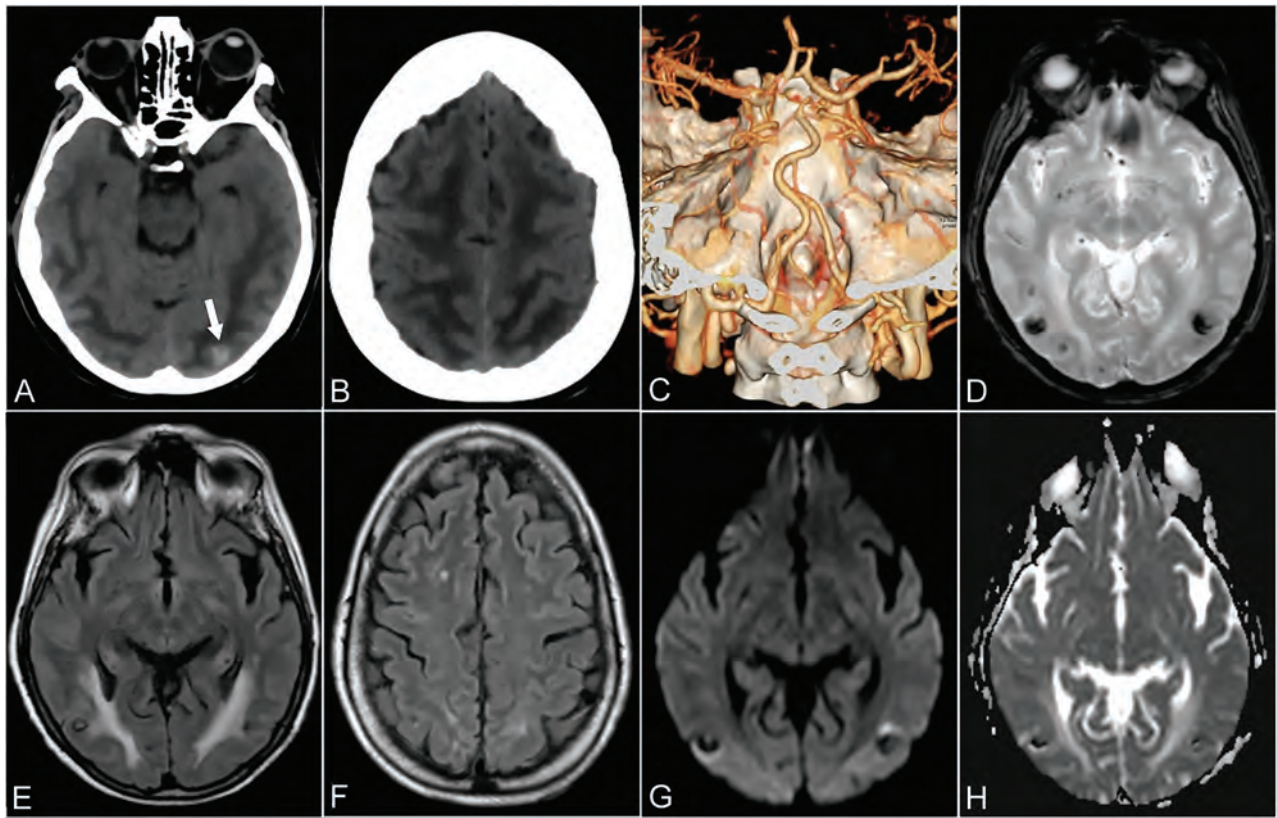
Patient 6. A 64-year-old woman presenting with drowsiness and reduction in visual acuity. Baseline axial CT shows ill-defined, bilateral hemispheric, white matter hypoattenuation, sparing the adjacent cortex, tapering off in the polar aspect of the frontal lobes, consistent with vasogenic edema (A and B). A small hyperattenuating lesion is noted in the left occipital lobe, suggestive of focal bleeding (arrow, A). CTA VR reformatted imaging was unremarkable in appearance (C). Three weeks later axial T2* gradient recalled-echo (D), axial T2 FLAIR (E and F), DWI (G), and an ADC map (H) demonstrate a partial resorption of edema and the presence of bilateral focal predominantly hypointense lesions (E) characterized by blooming (D) and signal blackout (G and H) in keeping with focal hemorrhage.
